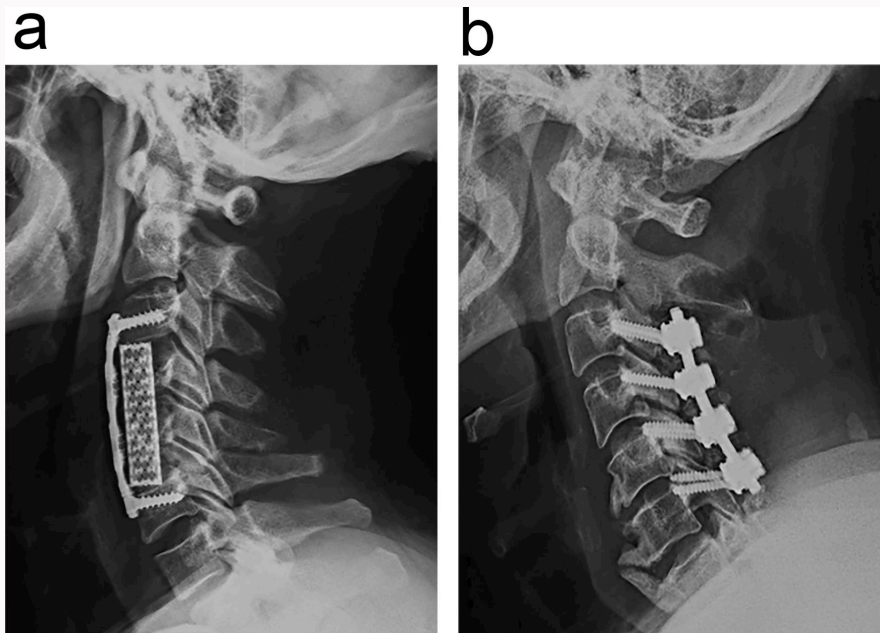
Lateral radiographs after a) anterior decompression with fusion (49-year-old male two days postoperatively) and b) posterior laminectomy with fusion (47-year-old male two days postoperatively).
